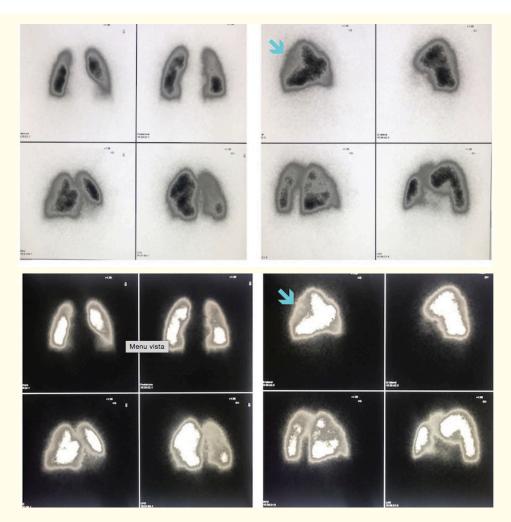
Imagines of perfusion scintigraphy: an hypoperfusion triangle-shaped area is identified on the apical segment of the right inferior pulmonary lobe suggestive of pulmonary infarction.
